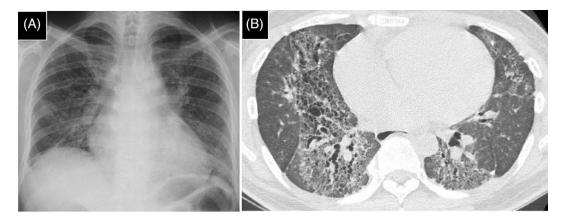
(A) Chest radiograph on admission showing enlarged cardiac silhouette and enhanced interstitial lung shadow. (B) Computed tomography scan of the chest revealing extensive reticular shadows and bronchiectasis in the whole lung field.
